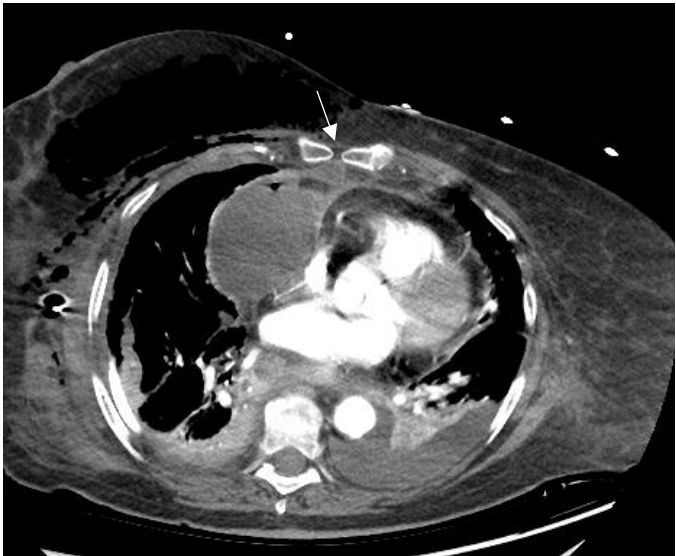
Diagnostic CT showing sternal foramen
